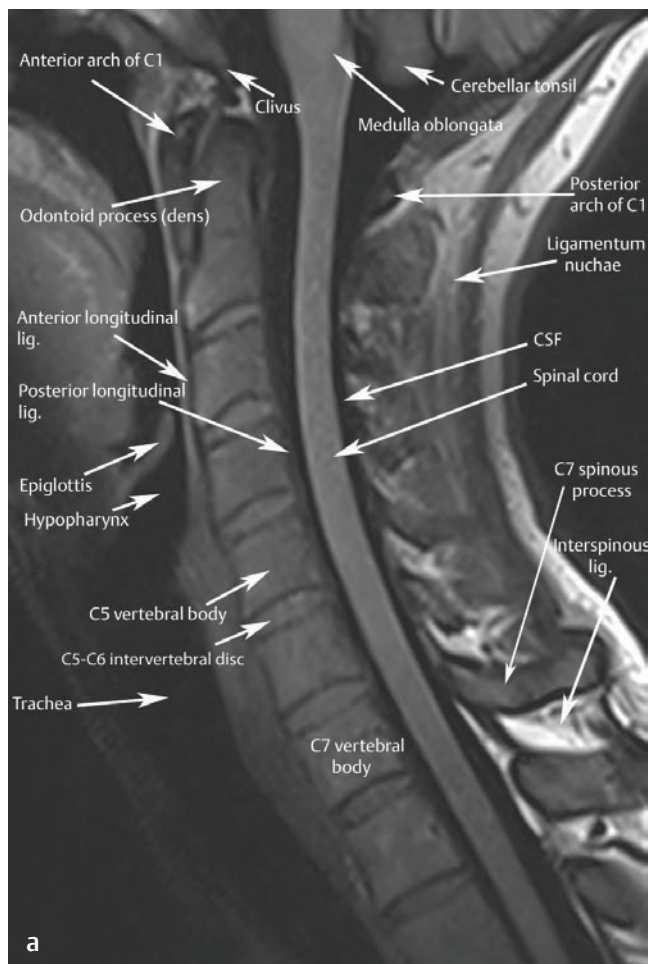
This (a) sagittal T1-weighted midline image and (b) artist's sketch of the cervical spine depict the cervical cord, CSF, and the anterior and posterior longitudinal ligaments, as well as the anterior and posterior elements of the cervical spine and the intervertebral discs.[†]
